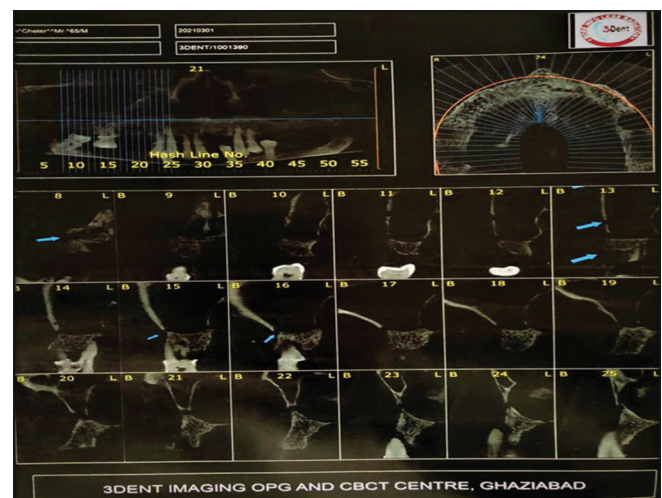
Cone beam computed tomography of buccal cutaneous plate (Maxilla)
